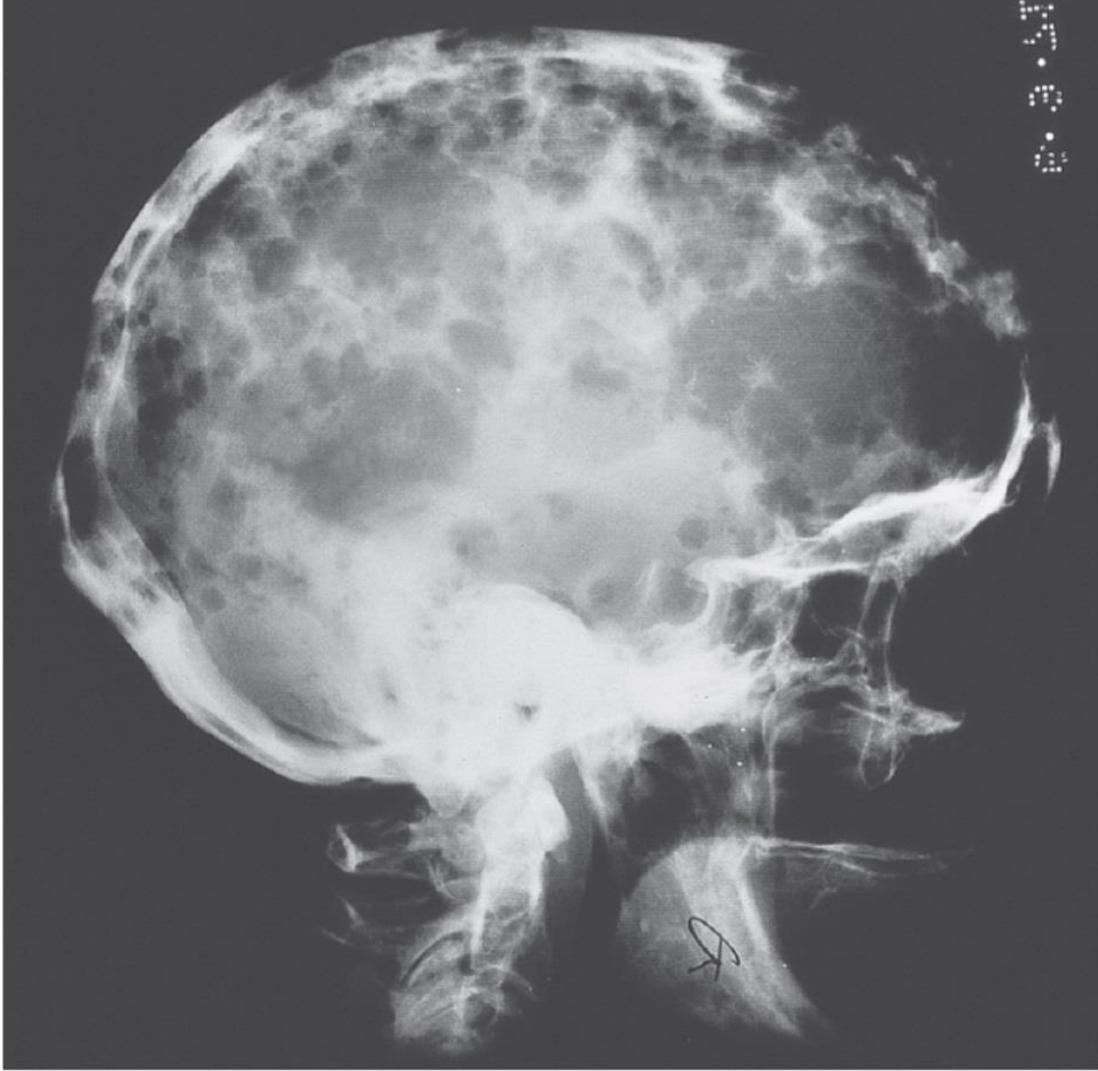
Skull X-ray in multiple myeloma showing many 'punched-out' lesions.
